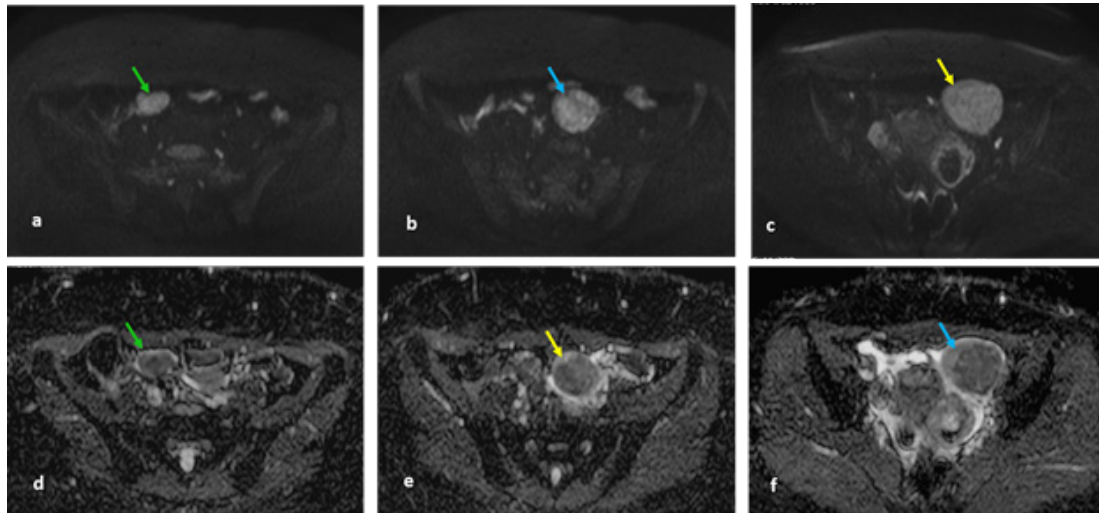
MRI shows three tumors with high signal intensity on axial diffusion-weighted imaging (b1000) (a-c) and low signal intensity on axial ADC map (d-f), corroborating the presence of restricted diffusion.
